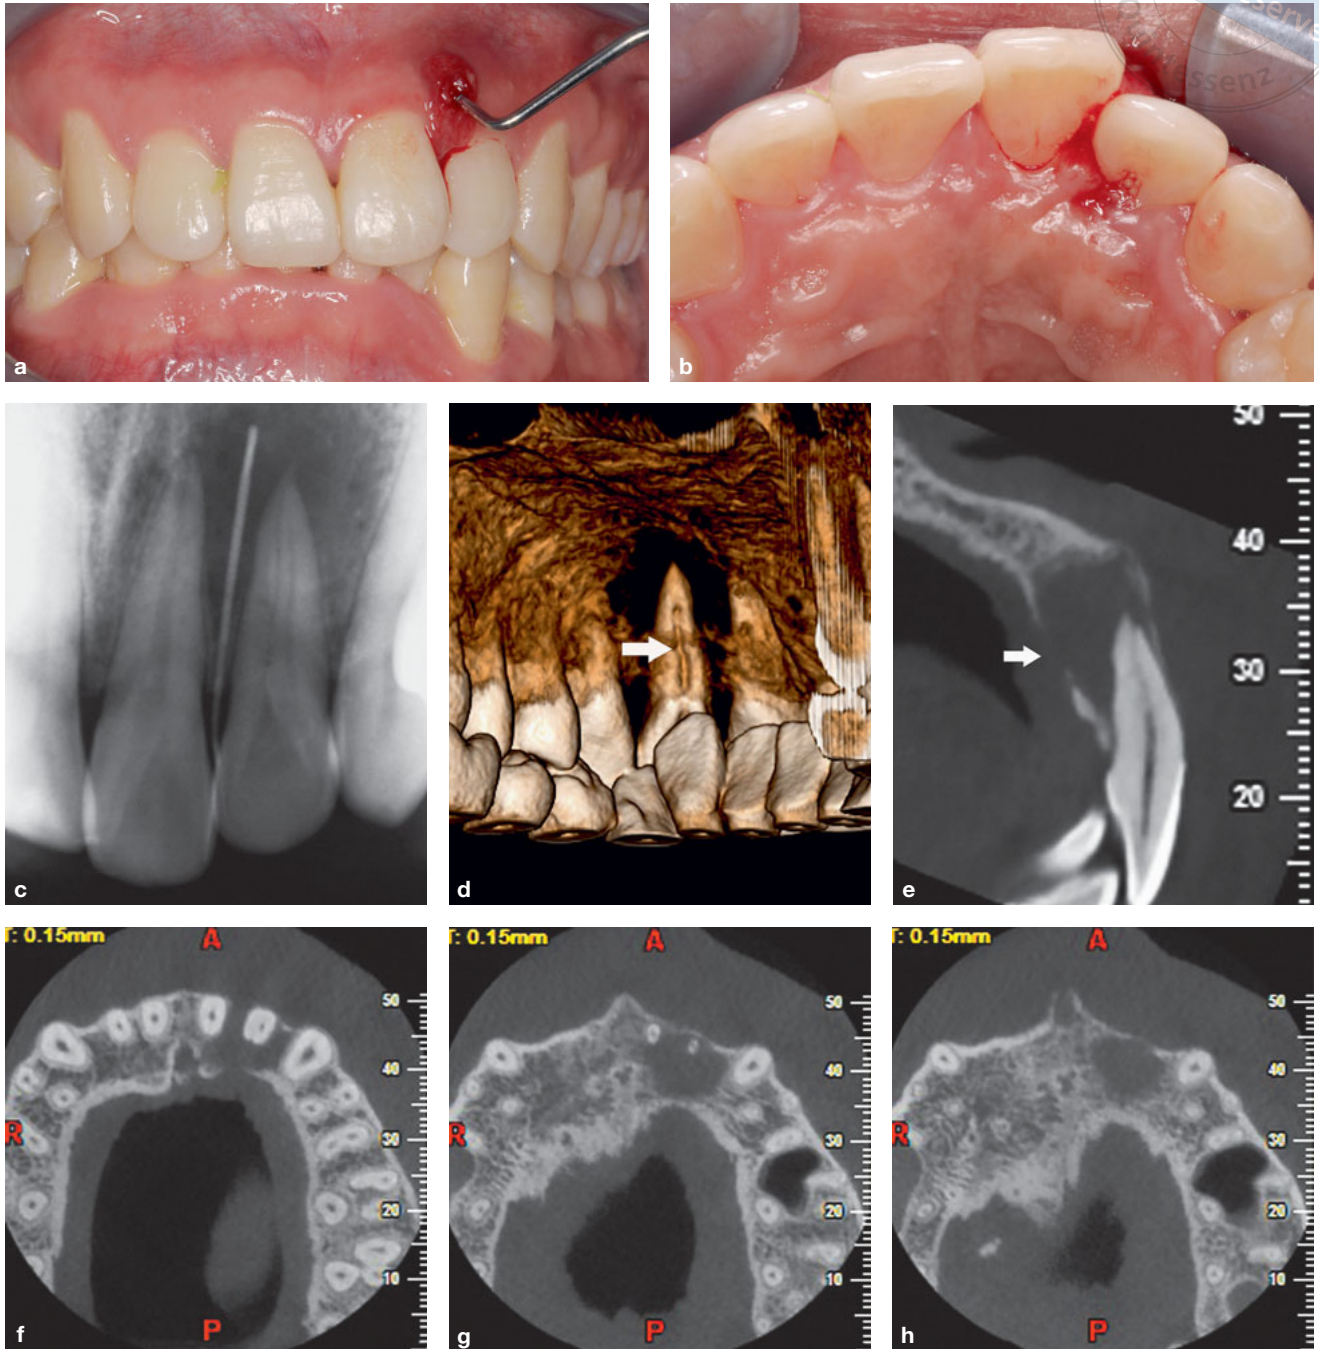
(a) The maxillary left lateral incisor. A preoperative clinical photograph shows a draining sinus tract on the labial gingiva. (b) A palatogingival groove was detected on the maxillary left lateral incisor, accompanied by a 12-mm periodontal pocket in the mid-palatal region. (c) A sinus tract that was traceable to the periradicular radiolucency associated with the maxillary left lateral incisor was detected with a gutta-percha cone. (d) A palatogingival groove was clearly revealed by CBCT and was found to extend from the coronal third to the apical third of the root. (e)–(h) A serious bone defect around the tooth was observed with CBCT. The tooth was considered to have a very poor prognosis.
